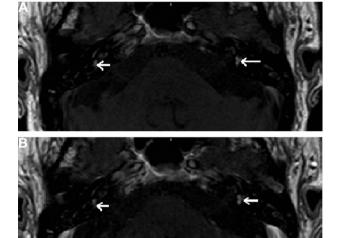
Internal auditory canal MRI. A. T1-weighted image. B. Contrast-enhanced T1-weighted image. The arrows show the spontaneous strong signal of the right and left posterior labyrinths.
